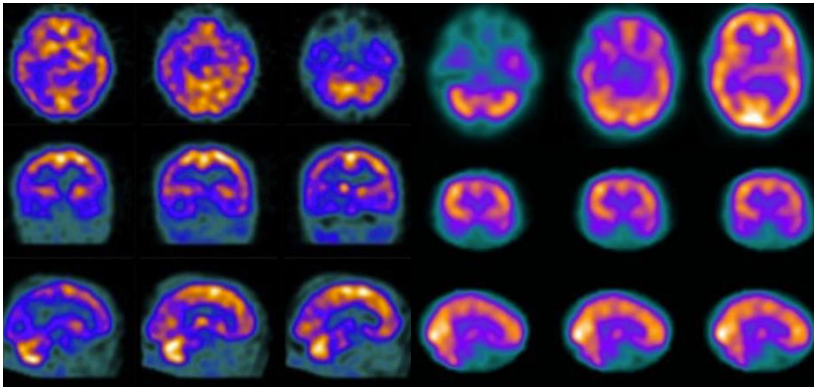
Left - Tc99m SPECT study demonstrating bilateral temporal hypoperfusion. Right – Normal study for comparison.
